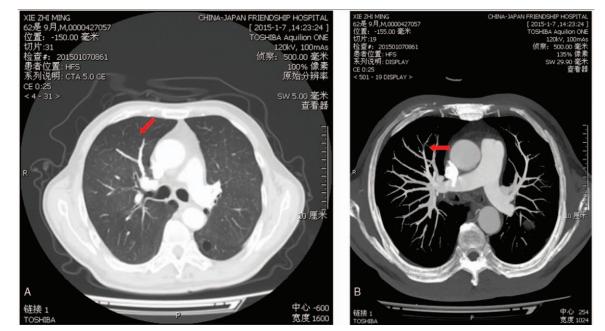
Computed tomography angiography shows cross-sections of the lungs. Red arrows indicate mild pulmonary embolism in the anterior segment of the pulmonary artery of the superior lobe.
